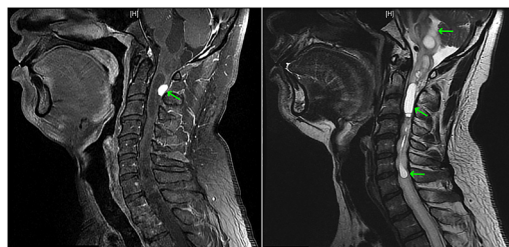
T1-weighted MRI, midline sagittal cut; arrow indicates solid tissue nodule of the haemangioblastoma (left). T2-weighted MRI, midline sagittal cut; arrows indicate extensive cystic structure of haemangioblastoma (right).
